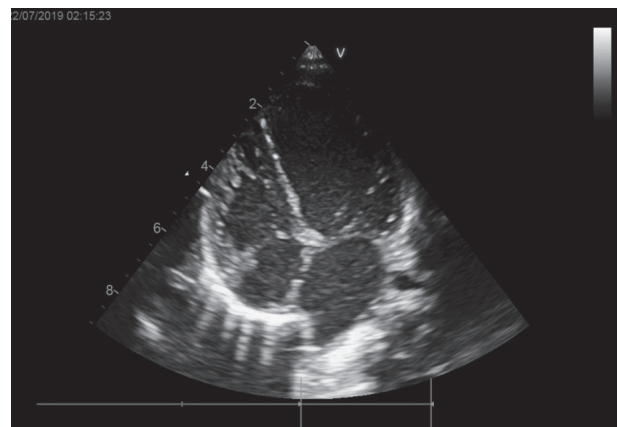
Echocardiogram at diagnosis, showing dilated left chambers (left ventricular end-diastolic diameter 31 mm, Z-score +6.7), mild left ventricular dysfunction (left ventricular ejection fraction 50%), and moderate-to-severe mitral regurgitation.
